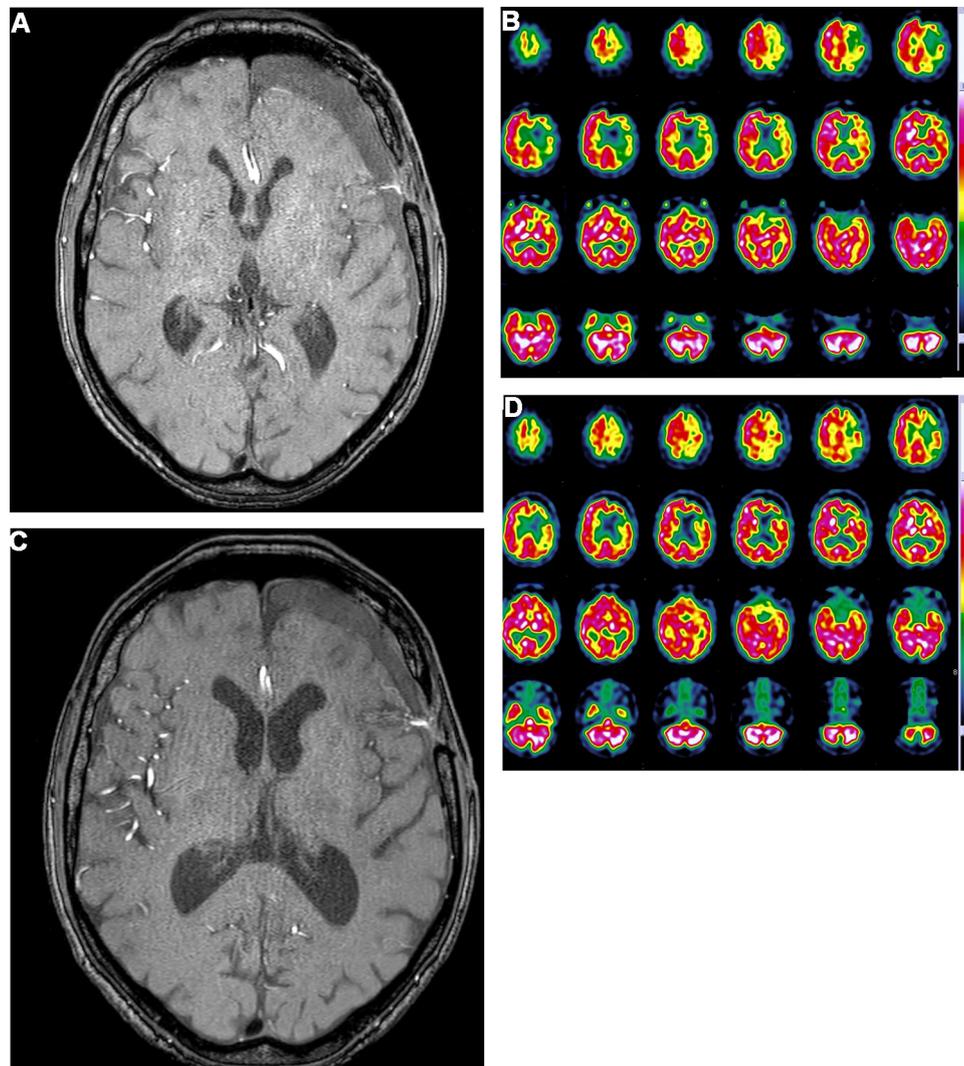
Patient 8, 55 years old, with deterioration of CVR in left middle cerebral artery territory related to unilateral left-side Moyamoya disease. STA-MCA anastomosis was performed but persistent CVR deterioration was noted on 99m Tc-HMPAO SPECT with acetazolamide challenge 3 months after treatment (Fig. 2A). MRI demonstrated a chronic subdural hematoma, with the STA stretched and thinned (Fig. 2B) and no flow was detected in the STA-MCA anastomosis by cranial Doppler. After administration of corticosteroids, MRI demonstrated regression of the chronic subdural hematoma (Fig. 2C) and transcranial Doppler revealed recanalization of the STA-MCA anastomosis. Improvement in cerebrovascular reserve was noted on 99m Tc-HMPAO SPECT with acetazolamide challenge (Fig. 2D).
